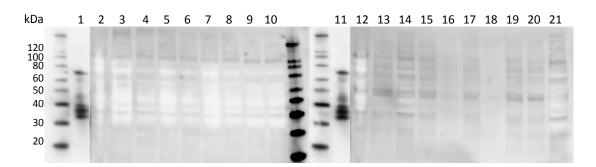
WB of transfected A549 cells. Cells were transfected with 1 and 3 μg DNA of the controls EGFP-KI VP1, EGFP-BKV-VP1 and KIPyV genome which was also co-transfected with BKPyV genome and the agno gene where the total amount of DNA was 3 μg. For comparison a pair of wells was transfected with 3 μg of KIPyV and CT-DNA. The samples are presented in Table 4.1. KI VP1 antibody dilution was 1:600.
